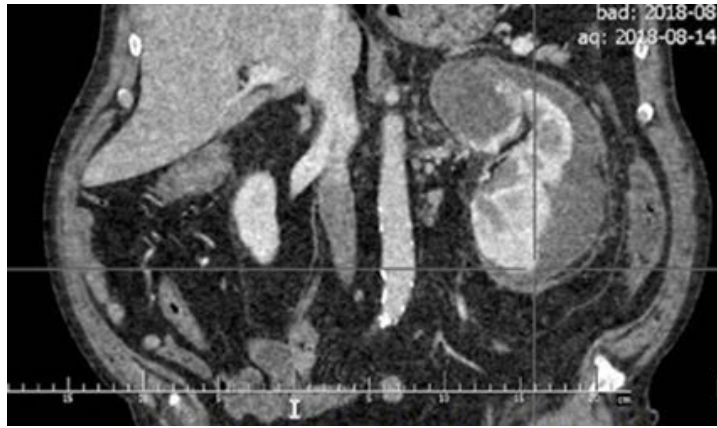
CT coronal image venous phase - a nodular cystic mass in the upper pole of the left kidney. A hematoma around the kidney.
